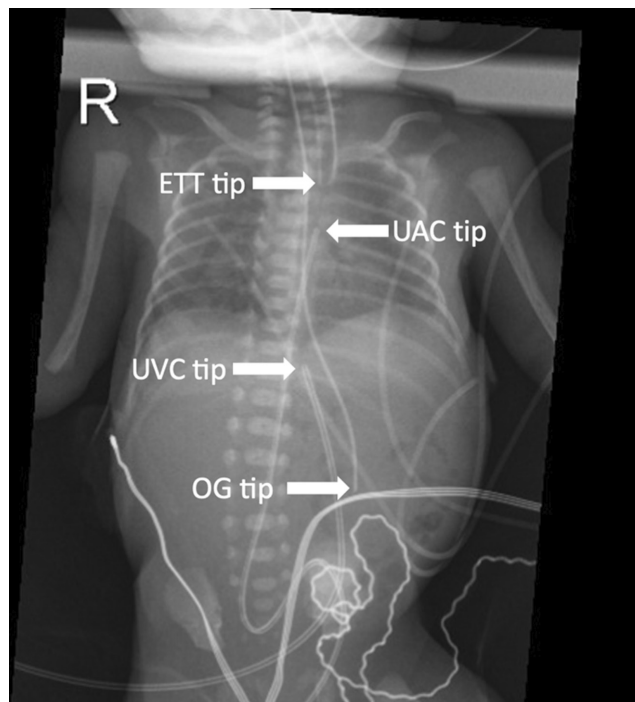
Radiograph showing the UVC position upon clinical deterioration.
